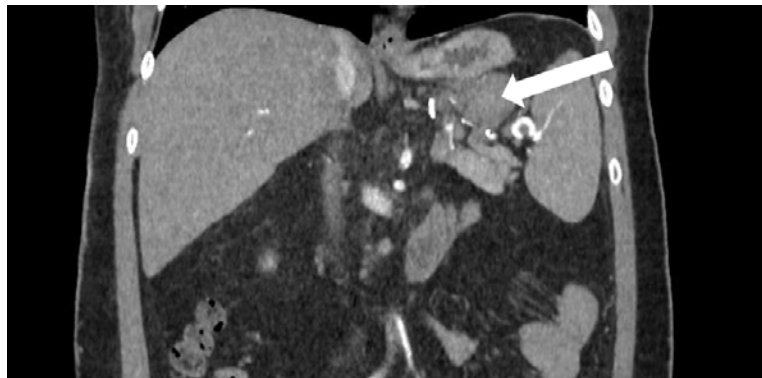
Abdominal multislice spiral computed tomography with intravenous contrast. Splenic artery aneurysm thrombosis (marked with an arrow)
